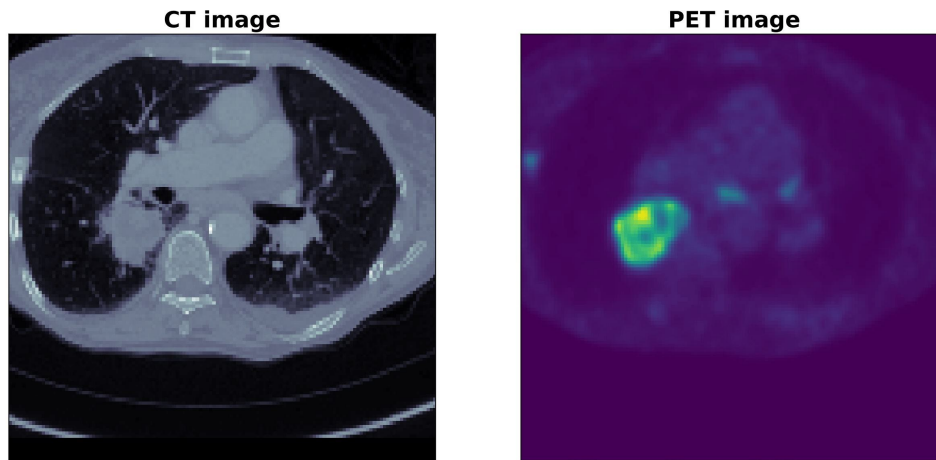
Comparison of a PET and CT patch of the same patient scan slice generated and used in this thesis. Both the benefits and shortcomings of CT and PET scans can be observed in this figure. Specifically, the figure shows that the CT patch clearly visualizes the lung region but poorly depicts the metabolic activity within this region. For the PET patch, the reverse can be observed
